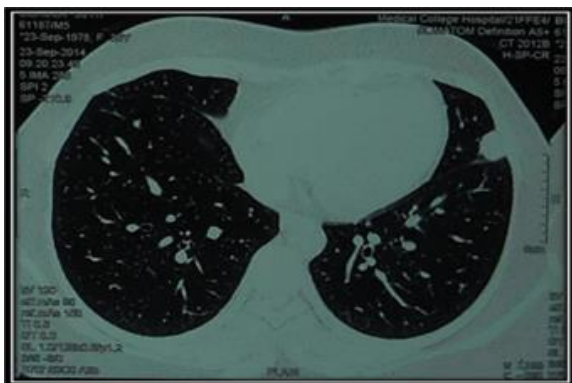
Chest CT axial section shows soft tissue density nodular lesion in the oblique fissure suggestive of granuloma in lung.
